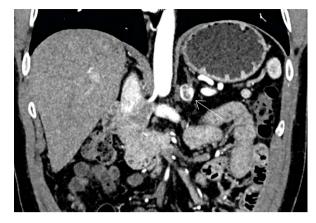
Same patient as in Figure 4. Coronal contrast-enhanced computed tomography (CT) scan depicts left adrenal mass showing heterogeneous enhancement suggestive of pheochromocytoma
